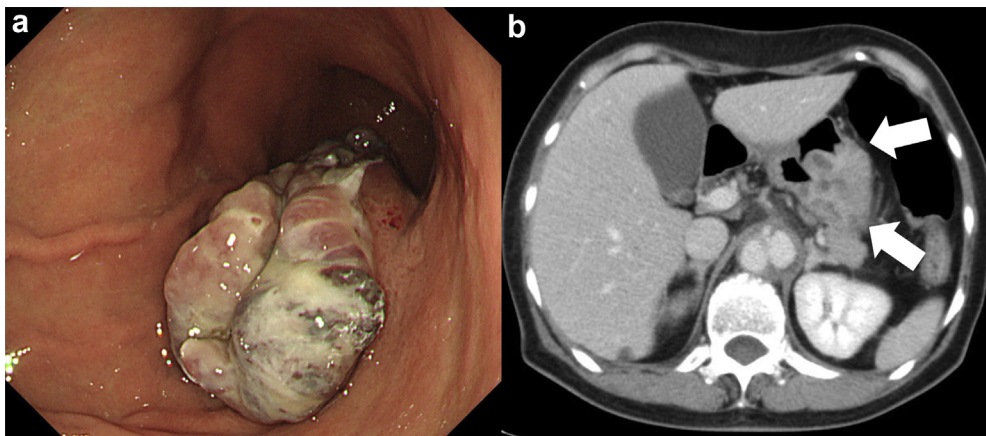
Gastric metastasis on the greater curvature was detected on upper endoscopy and enhanced computed tomography. a, Representative endoscopy image; b, dense thickening of the gastric wall is evident (*white arrows*: lesion).
